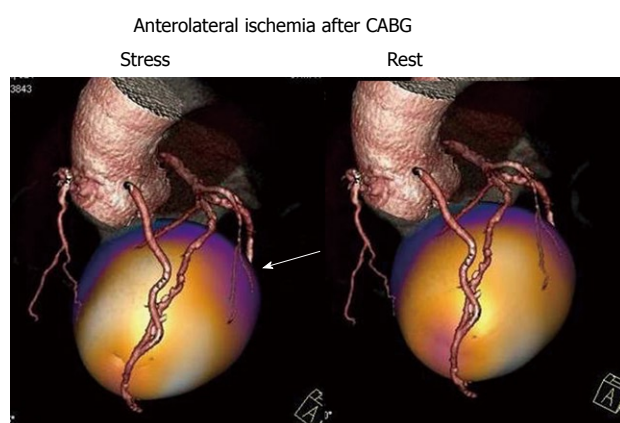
Fusion image reveals that the ischemic area in the basal anterolateral region shown by single photon emission computed tomography image is perfused by small vessels or has no corresponding artery assessed as imaging artifacts. Thus, the fusion image has increased diagnostic confidence for the detection of the culprit lesion in patients with coronary artery bypass grafting.
